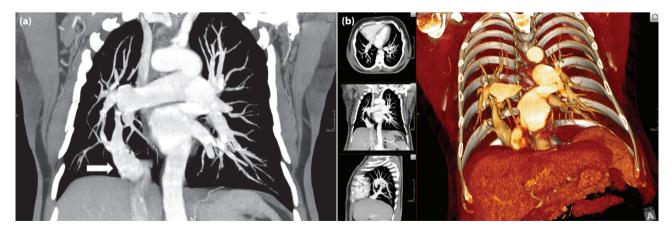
Scimitar syndrome in a 56-year-old male: (a) Coronal reformatted maximum intensity projection (MIP) image demonstrating the anomalous scimitar vein draining the hypoplastic right lung into the inferior vena cava (white arrow). (b) Volume rendering (VR) reconstructed computed tomography (CT) image showing the previously mentioned anomalous venous drainage (scimitar vein).
